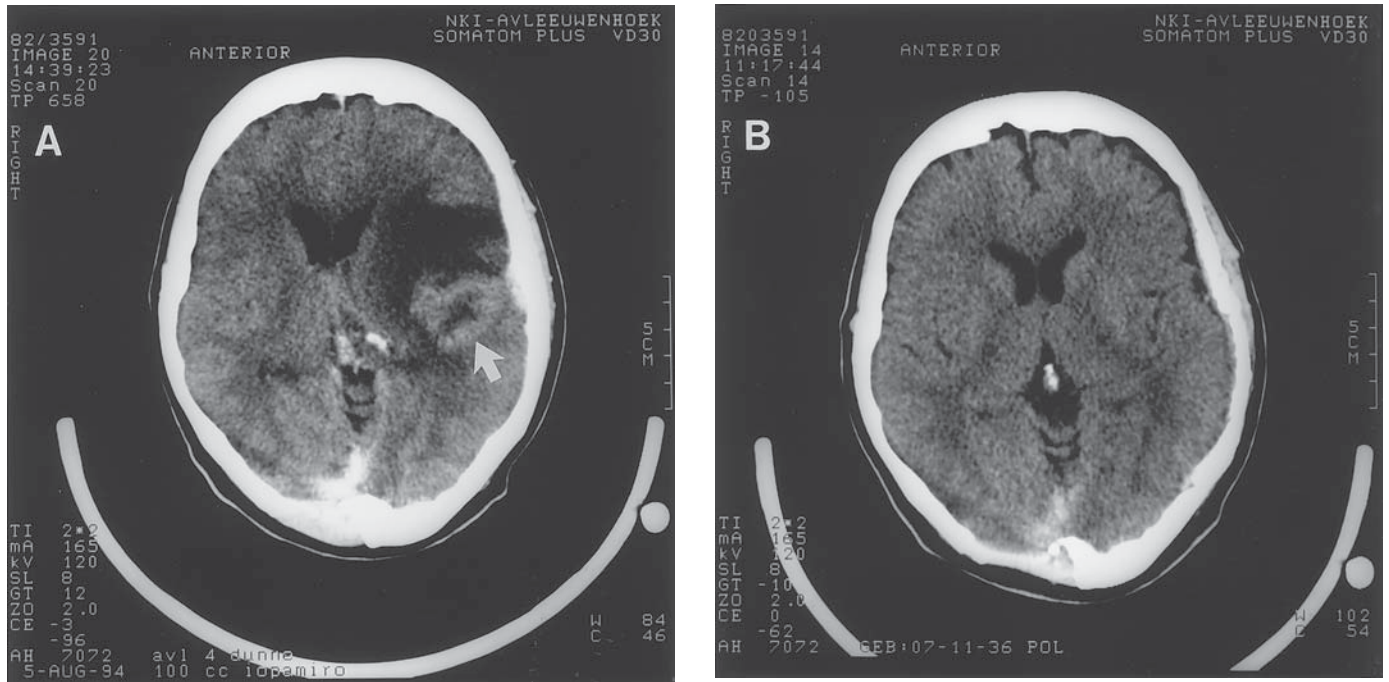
Brain metastasis; complete remission following systemic chemotherapy. Pretreatment CT scan (A) shows contrast enhancing lesion (arrow) with surrounding edema. Complete remission after CMF chemotherapy (B), that persisted until death due to systemic disease after 19 mo.
